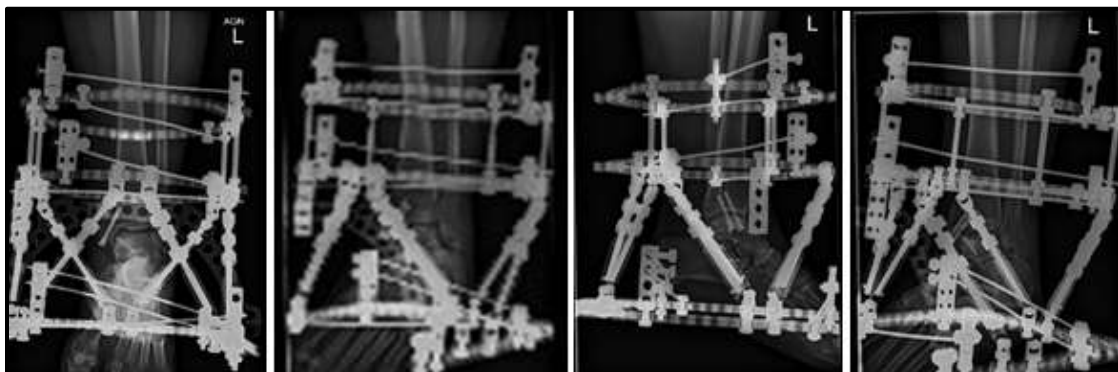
X-Rays of patient after Medial Malleolar Osteotomy followed by Distraction Arthroplasty.
